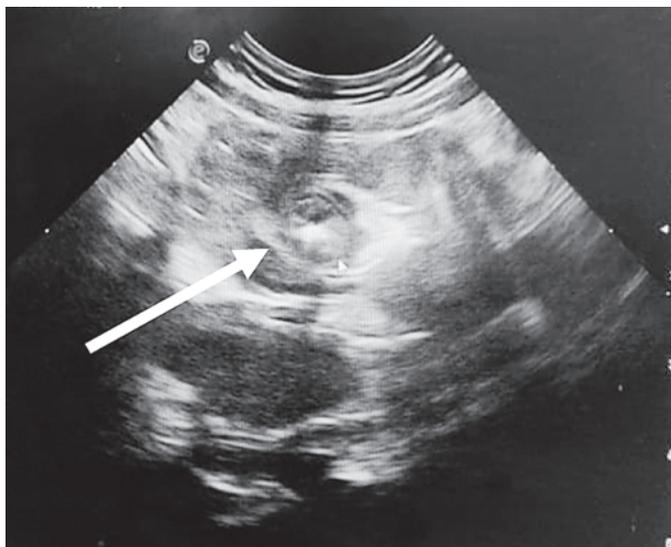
Ultrasound showing intussusception
